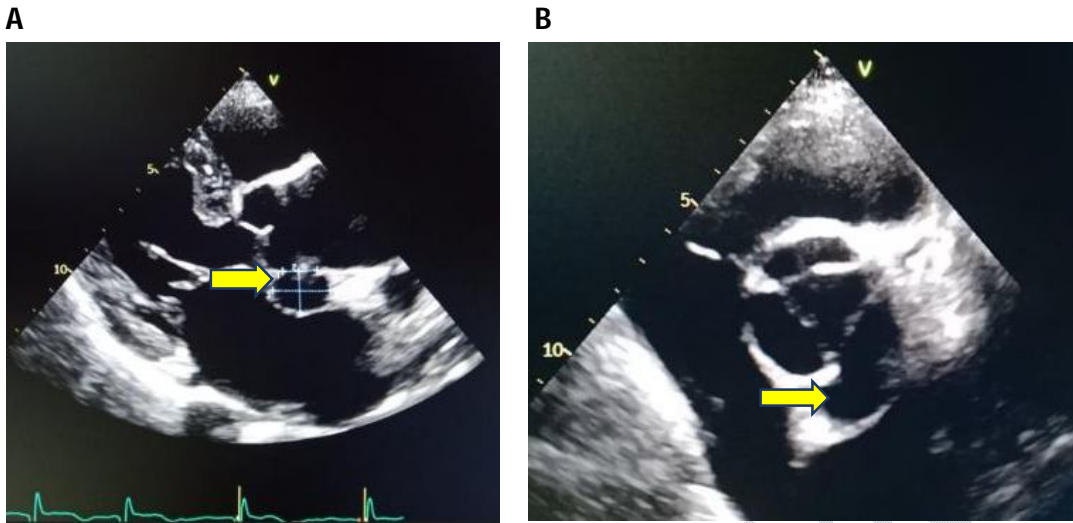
A -Transthoracic echocardiography (TTE) long axis view: -shows a saccular aneurysm on the posterior wall of the aorta next to the posterior cusp aortic valve
